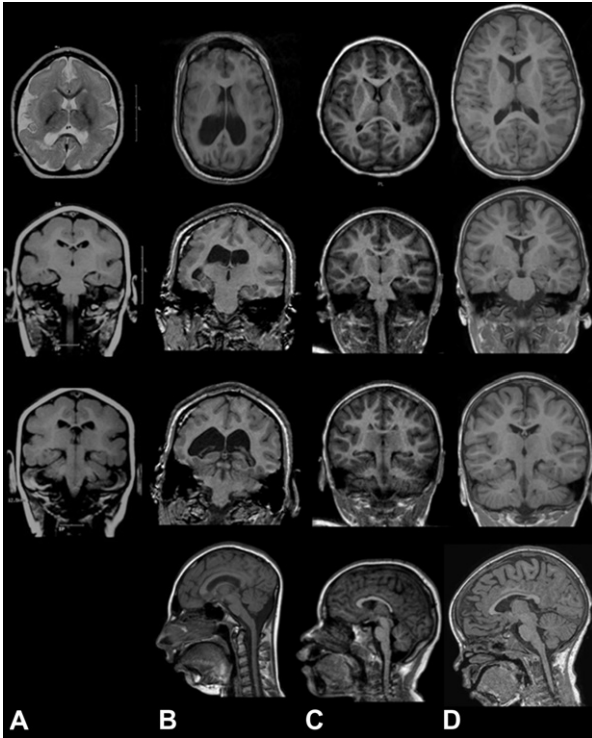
MRI findings from patients exhibiting microcephaly caused by (A) *WDR62* (from [Nicholas et al., 2011](#)); (B) *ASPM* mutation, and (C) 1q43-q44 microdeletion syndrome compared to (D) control subject (from [Passemard et al., 2009b](#)). Axial, coronal, and sagittal magnetic resonance images confirm the clinical diagnosis of microcephaly, with distinct presentation depending on the molecular diagnosis: pachygyria and impressive gyral simplification close to microlissencephaly due to *WDR62* mutation (A) unilateral, polymicrogyria and gyral simplification associated with *ASPM* mutation and microcephaly with more preserved gyration in patient C with 1q43q44 microdeletion.
